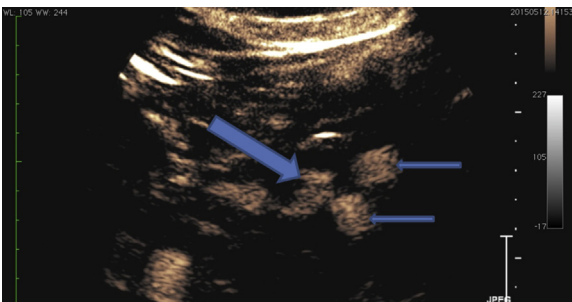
The postoperative contrast-enhanced ultrasonography shows a minimal type II endoleak in the aneurysmal sac (*large arrow*) with perfused legs of stent graft (*small arrows*).
